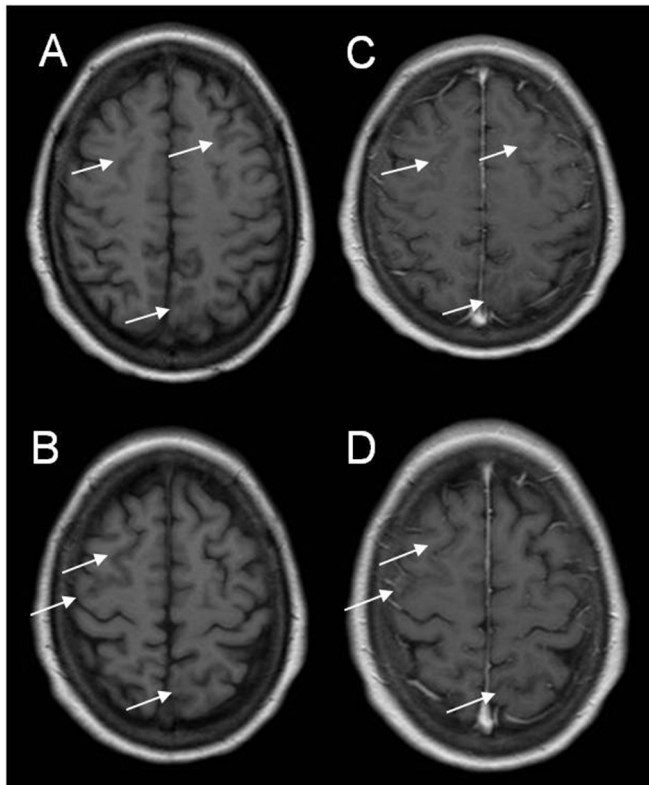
Axial T1-weighted images before (A, B) and after intravenous gadolinium administration (C, D) showed cortical areas with low signal intensity (arrows) without abnormal enhancement.
